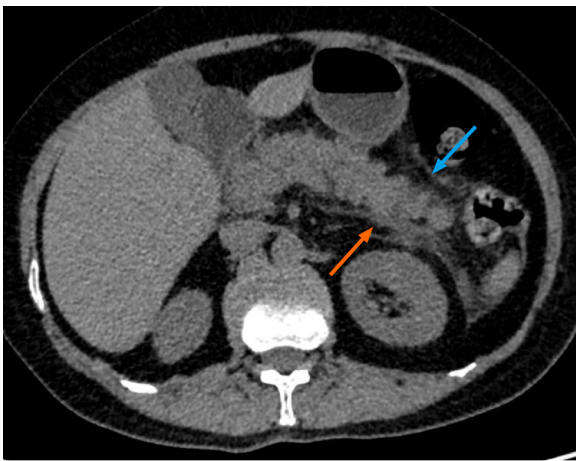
Acute viral pancreatitis in a coronavirus disease 2019 patient presenting with abdominal pain. Non-contrast axial computed tomography image of the abdomen in a case of suspected viral pancreatitis (intravenous contrast could not be administered due to a history of renal parenchymal disease with elevated creatinine) is shown. The distal body and tail of pancreas reveal fuzzy margins with peri-pancreatic fat stranding (blue arrow). Thickening of the left anterior conal fascia is noted with a streak of fluid in the left retro-mesenteric plane (orange arrow). Elevated serum amylase and lipase levels, in conjunction with these imaging findings, were highly suggestive of a diagnosis of acute viral pancreatitis in a patient with coronavirus disease 2019 presenting with abdominal pain.
